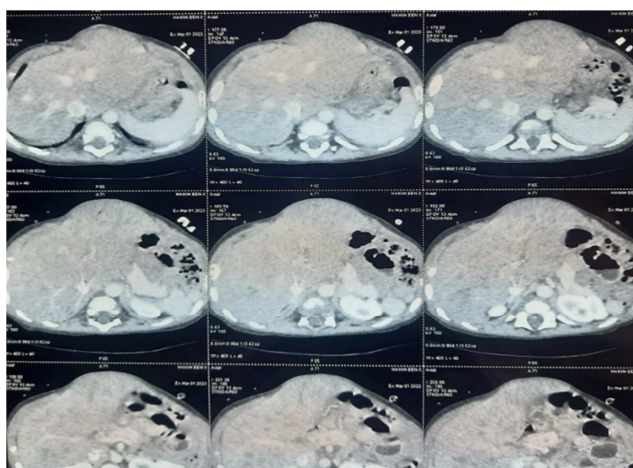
Thoracoabdominal CT-angiography, showing the supraumbilical hernia of segments II and III of the liver.
